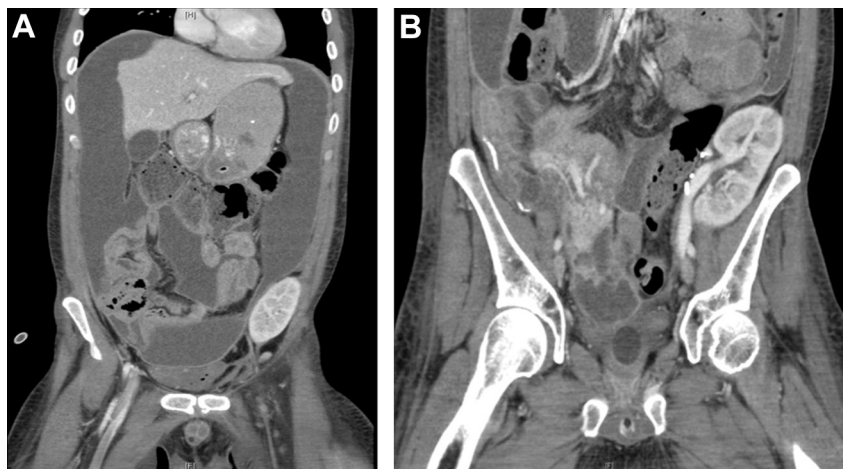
(A and B) CT with ruptured pancreatic cyst and generalized fluid collection.
